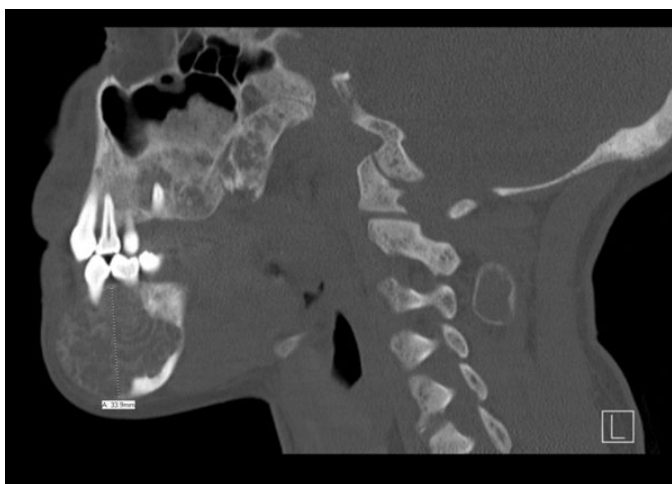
Computed tomography panorex without contrast showed protruding mass corresponding to the lytic lesion as shown in Figure 1.
